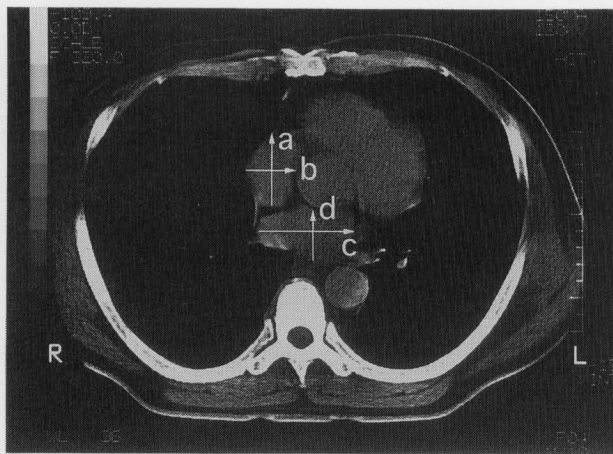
Atrial size on CT image.
